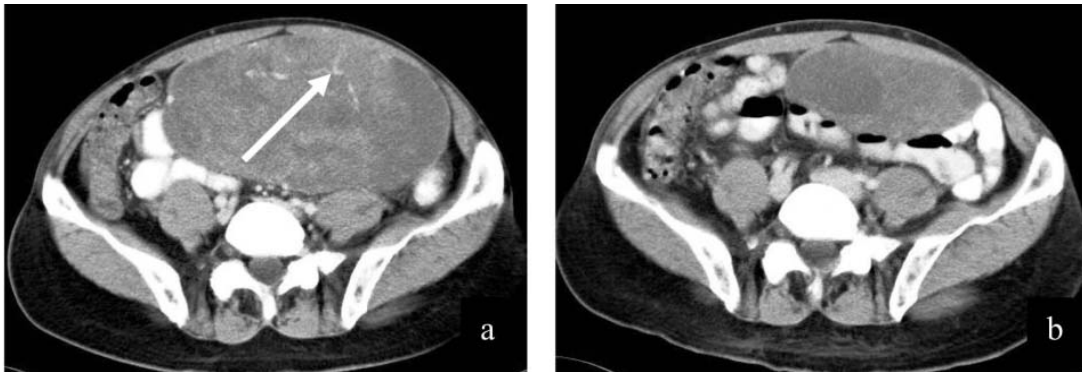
Contrast-enhanced CT scan of a 76-year-old male with large GIST in the mesentery. demonstrated evidence of tumor vessels (arrow) on pretreatment scan (a). After 2.5 months of treatment, tumor vessels were absent together with markedly decreased tumor size (b).
